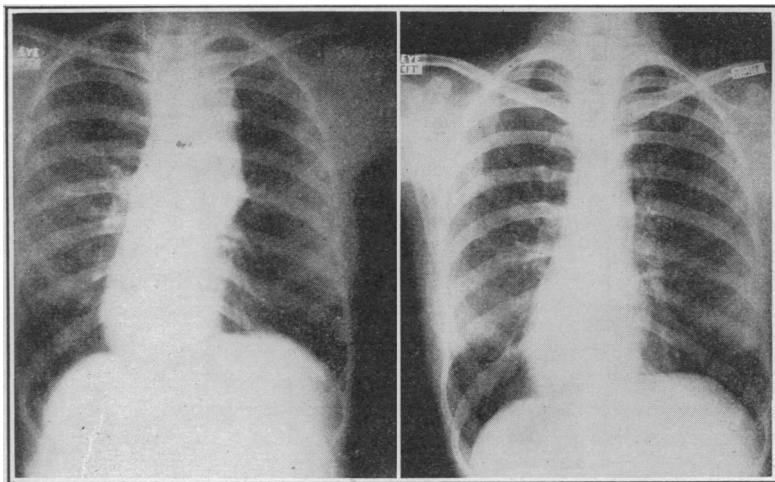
Roentgenogram made July 29, 1921, showing mediastinal tumefaction, especially on the right side. This was associated with enlargement of the cervical and axillary lymph nodes.
